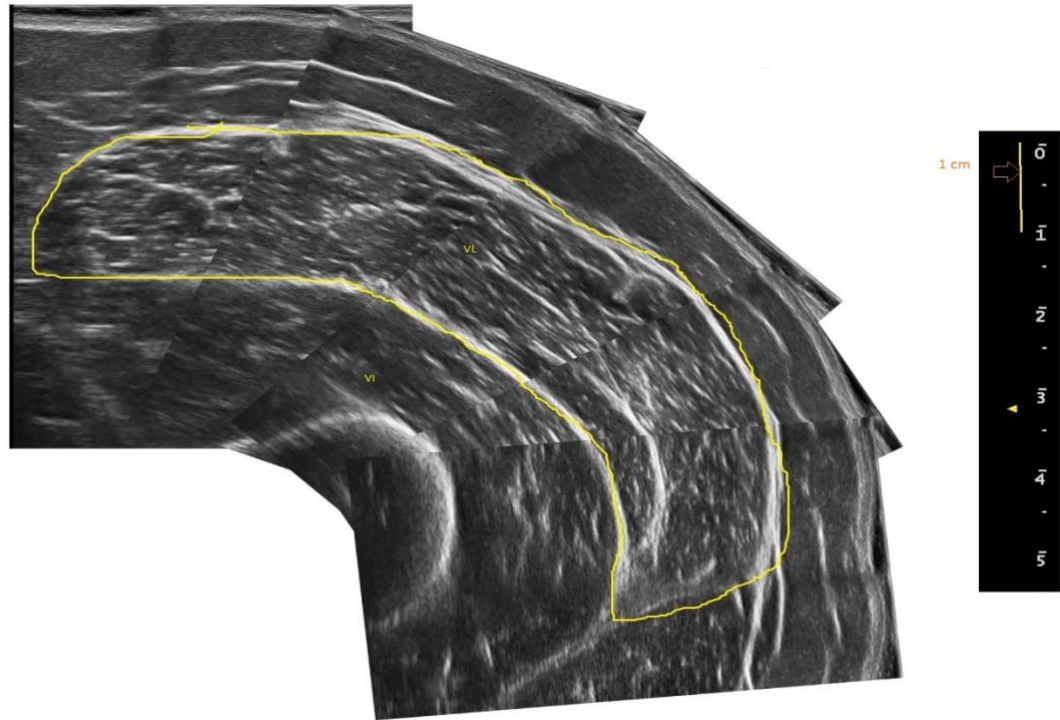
VL_{ACSA} measured using single transverse plane B-mode ultrasound scans and contour matched. VL= Vastus Lateralis, VI= Vastus Intermedius. Scan was obtained from a participant of the work described in the current thesis.
